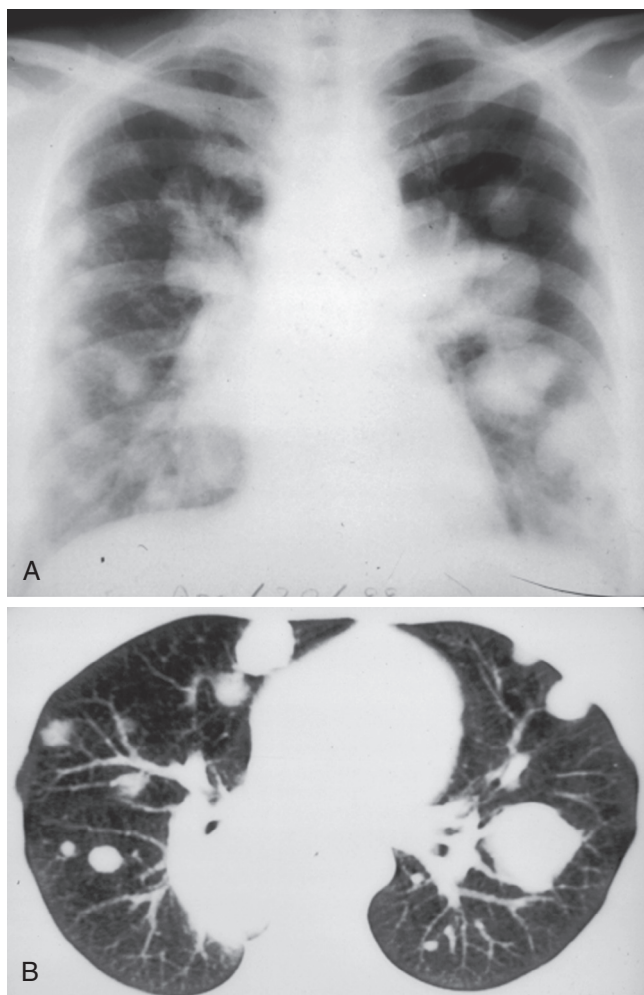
■ Benign metastasizing leiomyoma. These lesions occur in young women and are associated with leiomyomas of the uterus. A, Anteroposterior chest radiograph demonstrating multiple leiomyomas. B, The corresponding chest CT scan.
